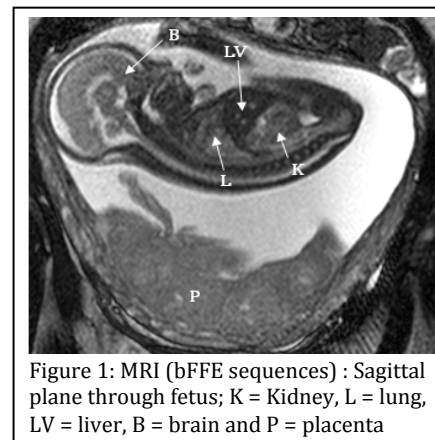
MRI (bFFE sequences) : Sagittal plane through fetus; K = Kidney, L = lung, LV = liver, B = brain and P = placenta
